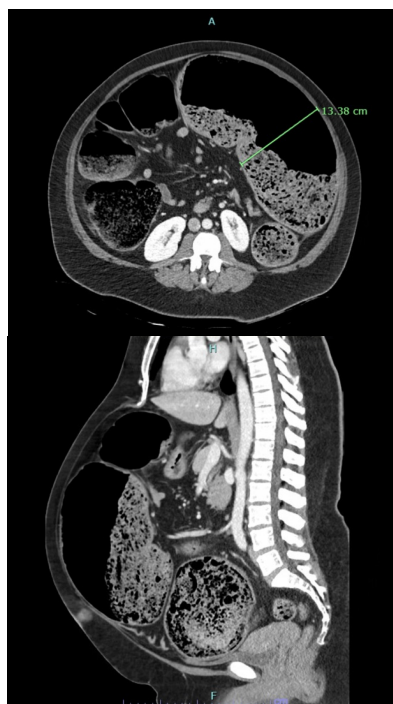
Admission CT showing distension of colon up to 14cm in the axial and sagittal planes
